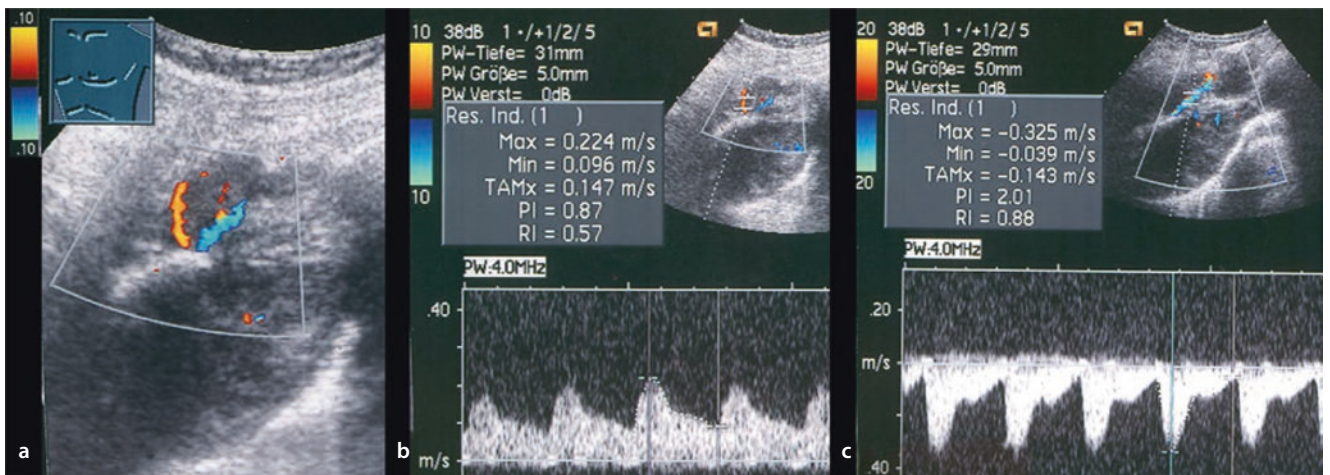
34-years old man with testicular carcinoma and chest wall metastasis. a In B-Mode and color Doppler a tumor formation infiltrating in the lung. b Spectral curve analysis shows a monophasic
